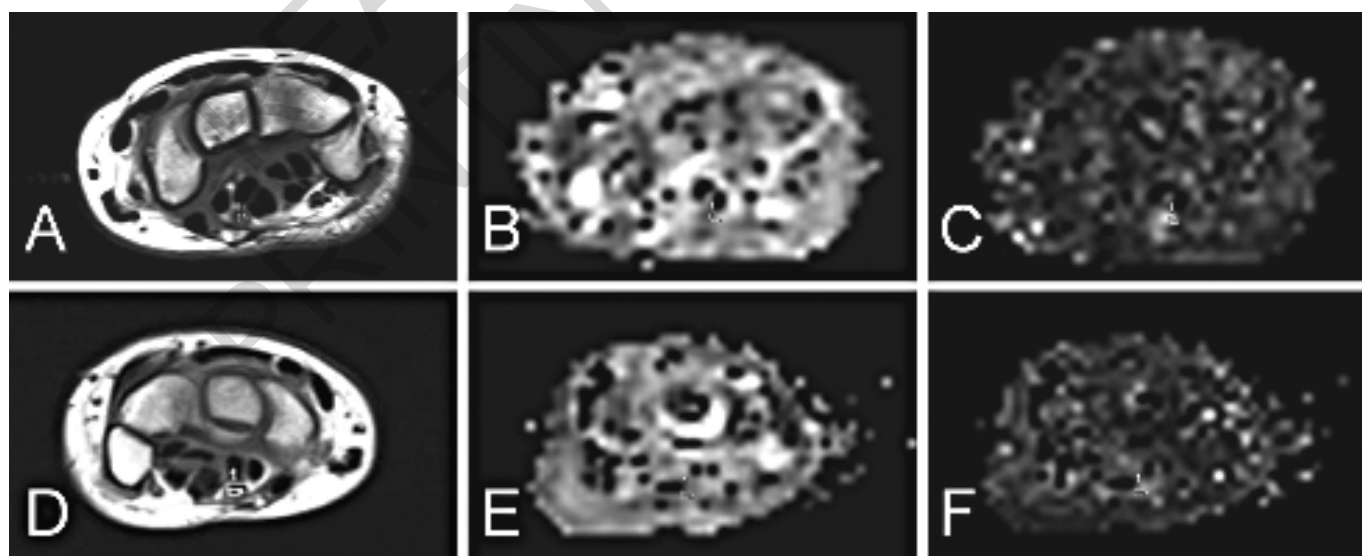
Right (lacerated, A; B; C) and left (normal, D; E; F) wrists of an 18-year-old female. T1-weighted spinechoaxial MR image (A) at the level of the pisiform bone shows right median nerve (region of interest-ROI). Corresponding ADC (B) and FA (C) maps show ROI placements to obtain mean ADC and FA values. Left wrist of same patient is evaluated using the similar method. Left median nerve and ADC and FA value measurements are demonstrated on T1-weighted spinecho axial MR image (D), corresponding ADC (E) and FA (F) maps.
